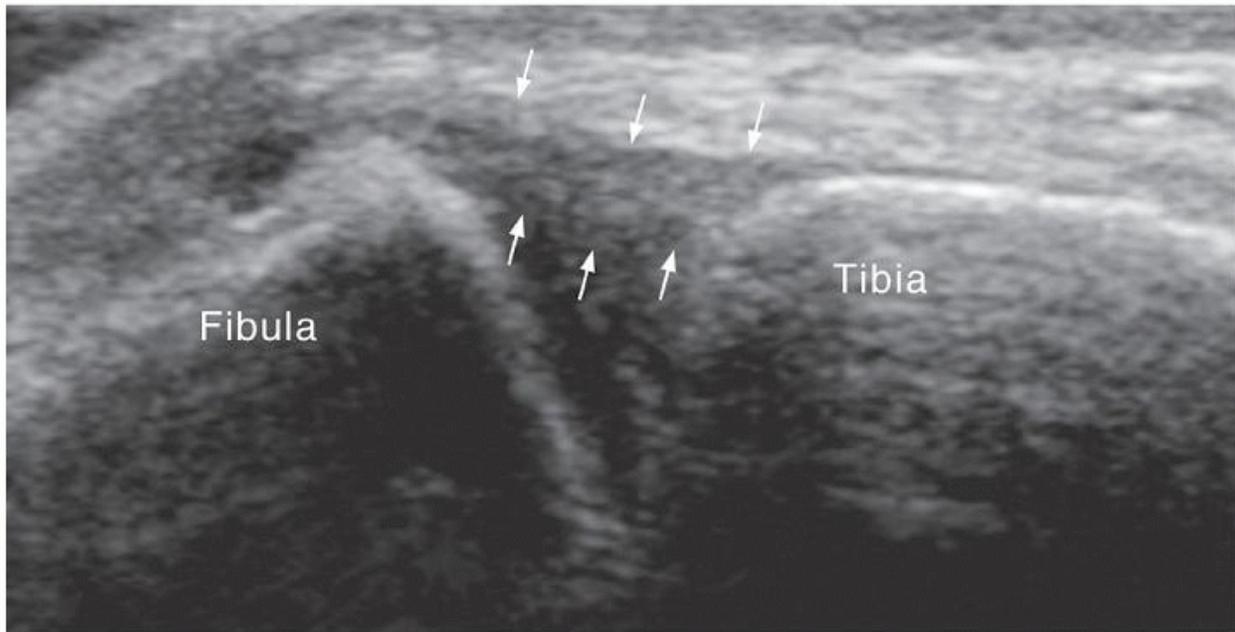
Transverse ultrasound showing normal anterior inferior tibiofibular ligament (arrows) with a wider attachment to the tibia than the fibula.
